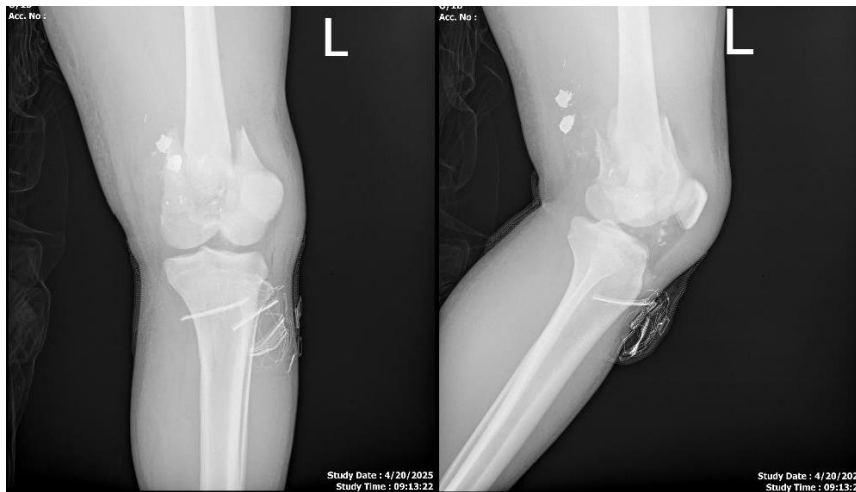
X-ray of the left genu during the patient's first referral.
